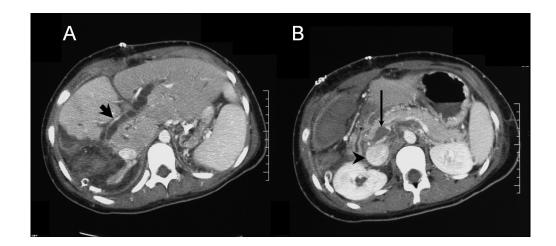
(Case 1) A. Contrast-enhanced computed tomography showing severe dilatation of intra-hepatic bile ducts of the liver remnant after right hepatectomy (arrow) and B. Portal vein thrombosis (arrow) and inferior vena cava dilatation (arrowhead). 249x111mm (150 x 150 DPI)
